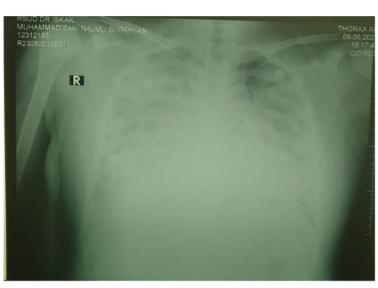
Chest X-ray of the patient shows diffuse pneumonic consolidations in both lung field and pulmonary edema bilateral
